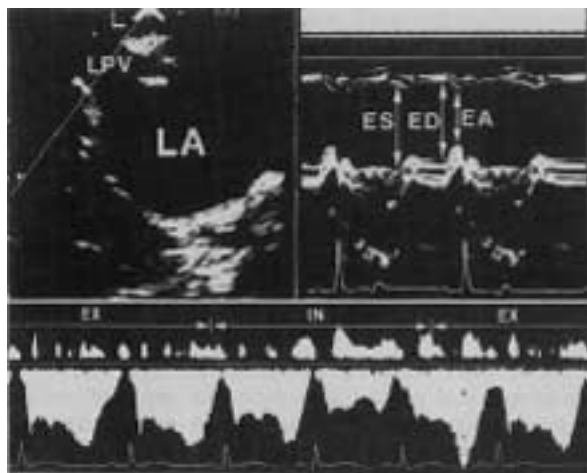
The imaging plane on the top demonstrates M-mode measurement of the left caudal pulmonary venous diameter (left) and the changes of pulmonary venous diameter during cardiac cycle (right). At the bottom, the pulsed Doppler wave form of pulmonary venous flow changes with respiration. Both the S wave and the D wave decreased during inspiration in comparison with expiration. EA=diameter during the end of left atrial contraction; ED=diameter during end-diastole; ES=diameter during end-systole; EX=expiration; IN=inspiration; LA=left atrium; LPV=left caudal pulmonary vein.
